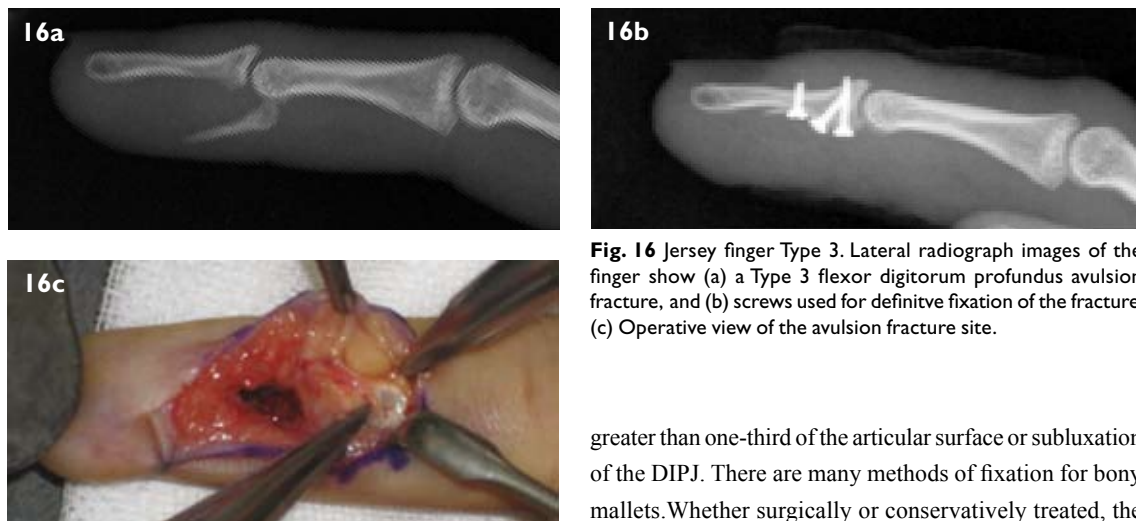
Jersey finger Type 3. Lateral radiograph images of the finger show (a) a Type 3 flexor digitorum profundus avulsion fracture, and (b) screws used for definitive fixation of the fracture. (c) Operative view of the avulsion fracture site.
